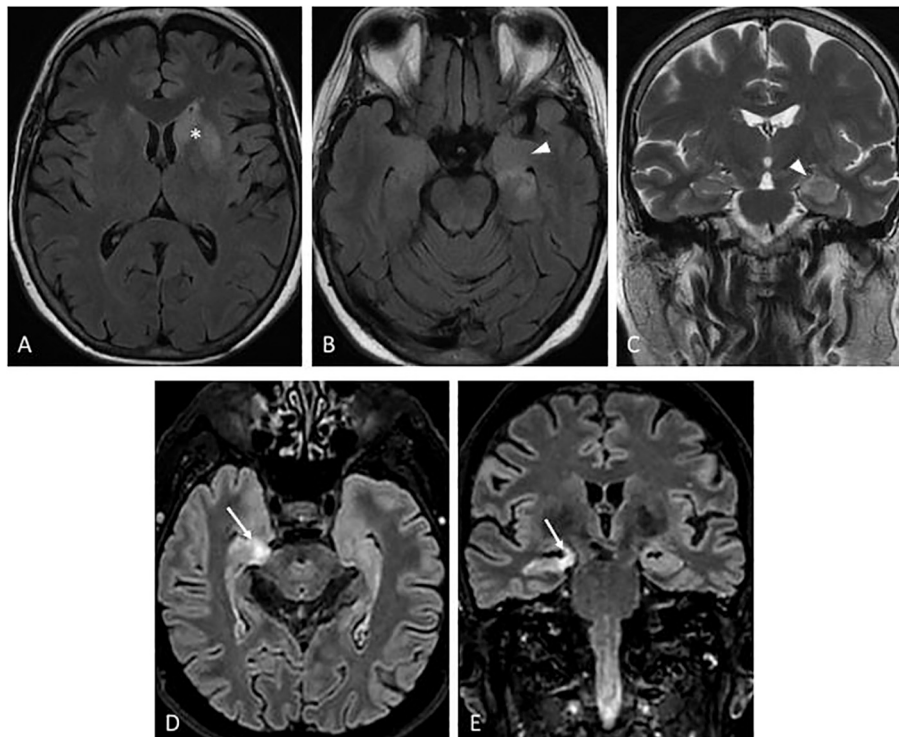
MRI of Sister #1. Axial FLAIR image (A) showing left striatum hyperintensity (star). Axial FLAIR (B) and coronal T2 (C) scans showing left hippocampus hyperintensity and swelling (arrowhead). MRI of Sister #2. Axial (D) and coronal (E) FLAIR scans showing right hippocampus hyperintensity (arrow).
